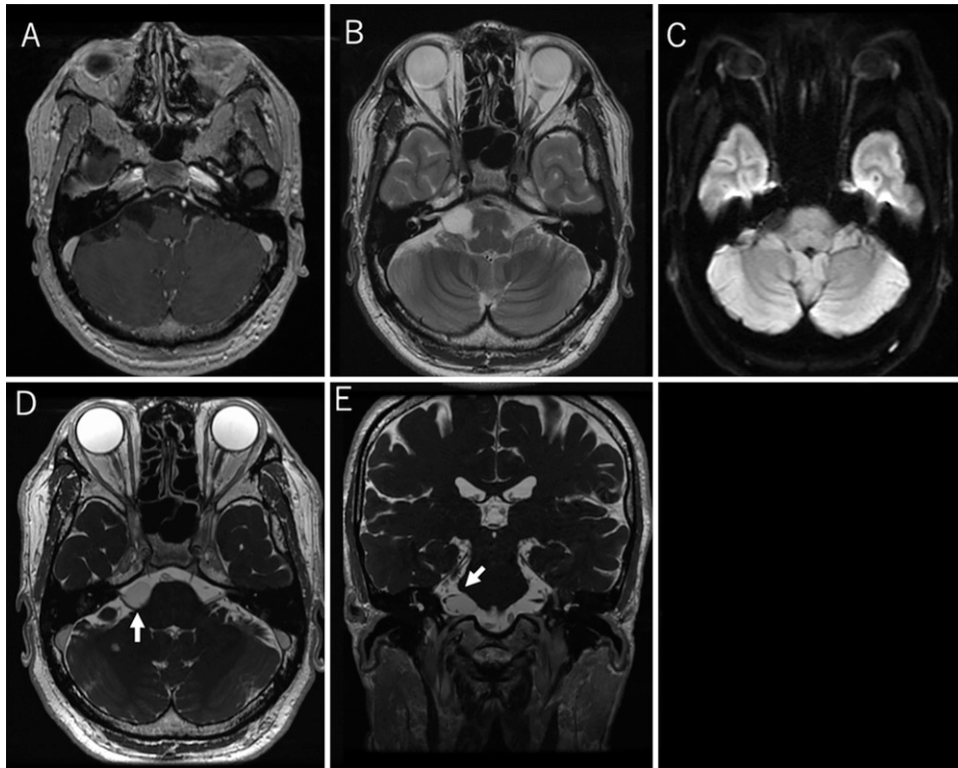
Preoperative MRI showing low intensity on contrast-enhanced T1-weighted images (A) and high intensity on T2-weighted images (B). Diffusion-weighted imaging reveals no lesions (C). Axial (D) and coronal (E) fast imaging employing steady-state acquisition images showing the cyst compressing the facial nerve at the REZ (arrows).
